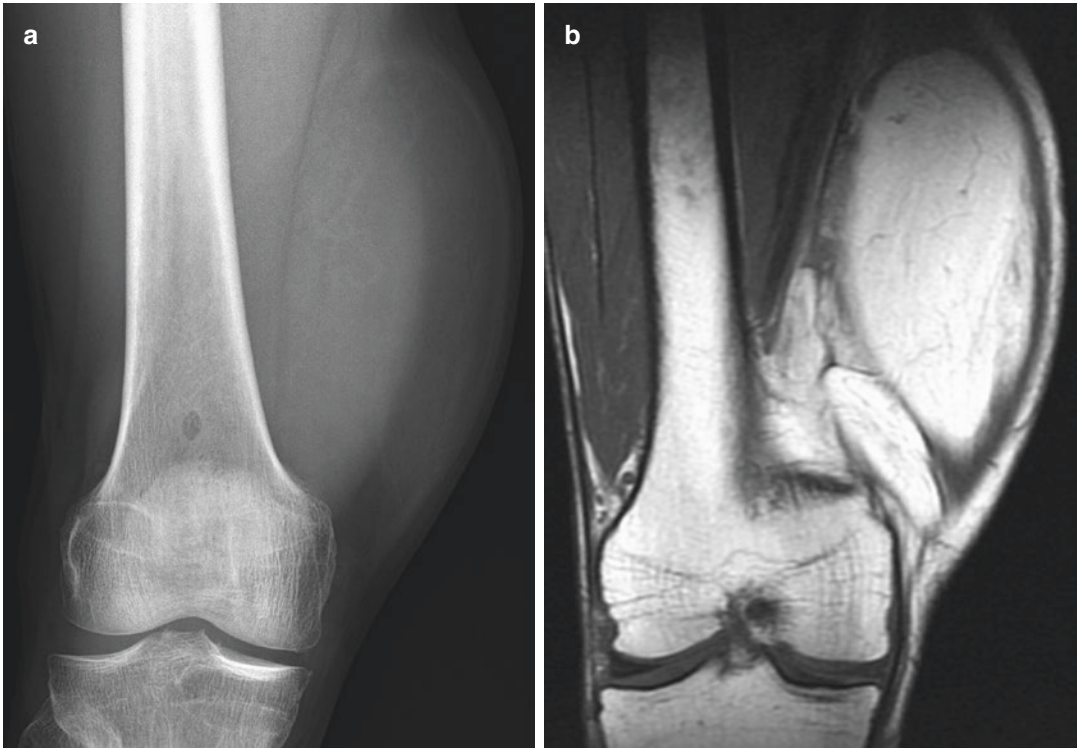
Well-differentiated liposarcoma. AP radiograph of the right knee (a) shows a large soft tissue mass with low density indicating fat component. Coronal T1WI (b)
